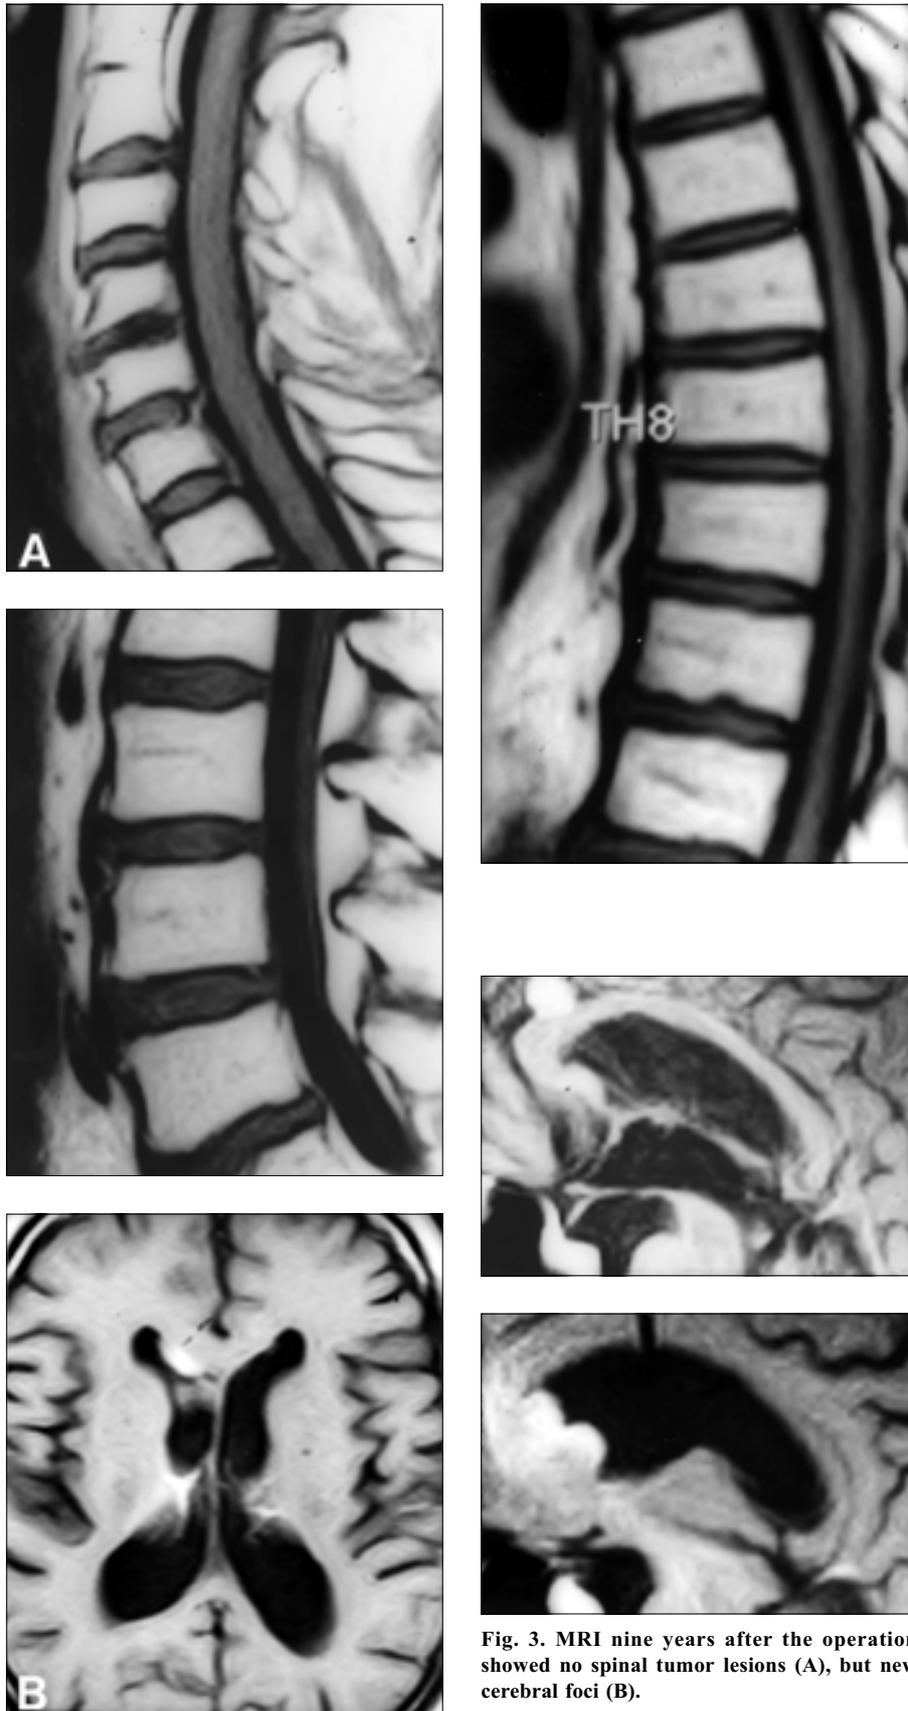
MRI nine years after the operation showed no spinal tumor lesions (A), but new cerebral foci (B).
